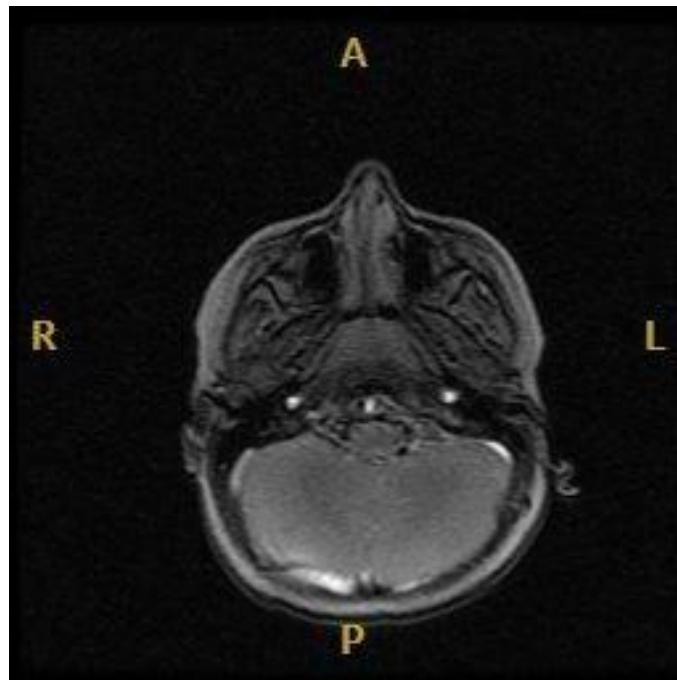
Horizontal plane of brain magnetic resonance imaging
